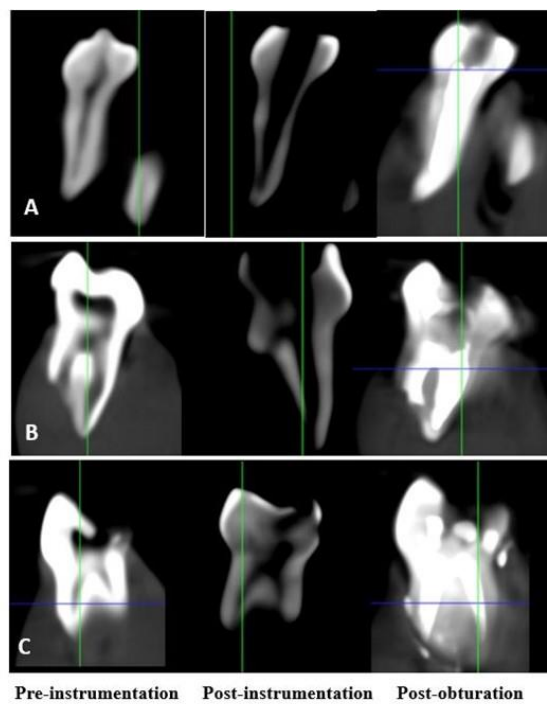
CBCT image of A. K-flex file B. ProTaper Next file C. Kedo S² file respectively
